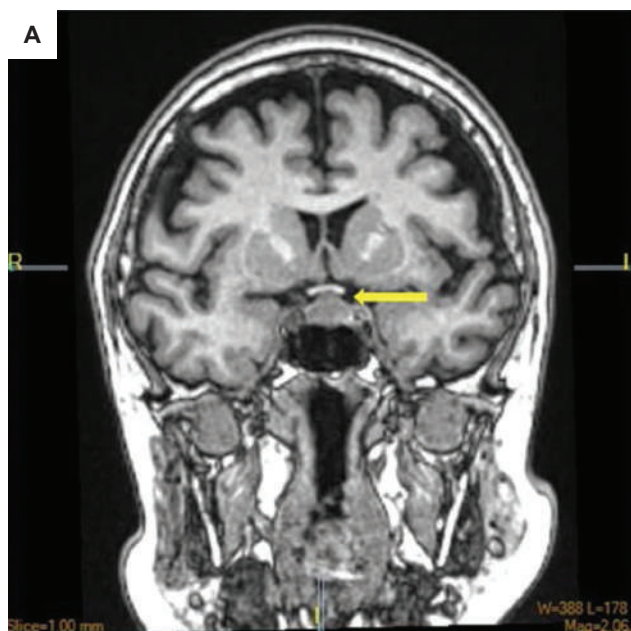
Cranial MRI upon recurrence of symptoms in (A) coronal and (B) sagittal views showing an enhancing left sellar nodule measuring 1.2 cm x 1.3 cm x 1.5 cm superiorly deviating the pituitary infundibulum to the right and abutting the optic chiasm.
